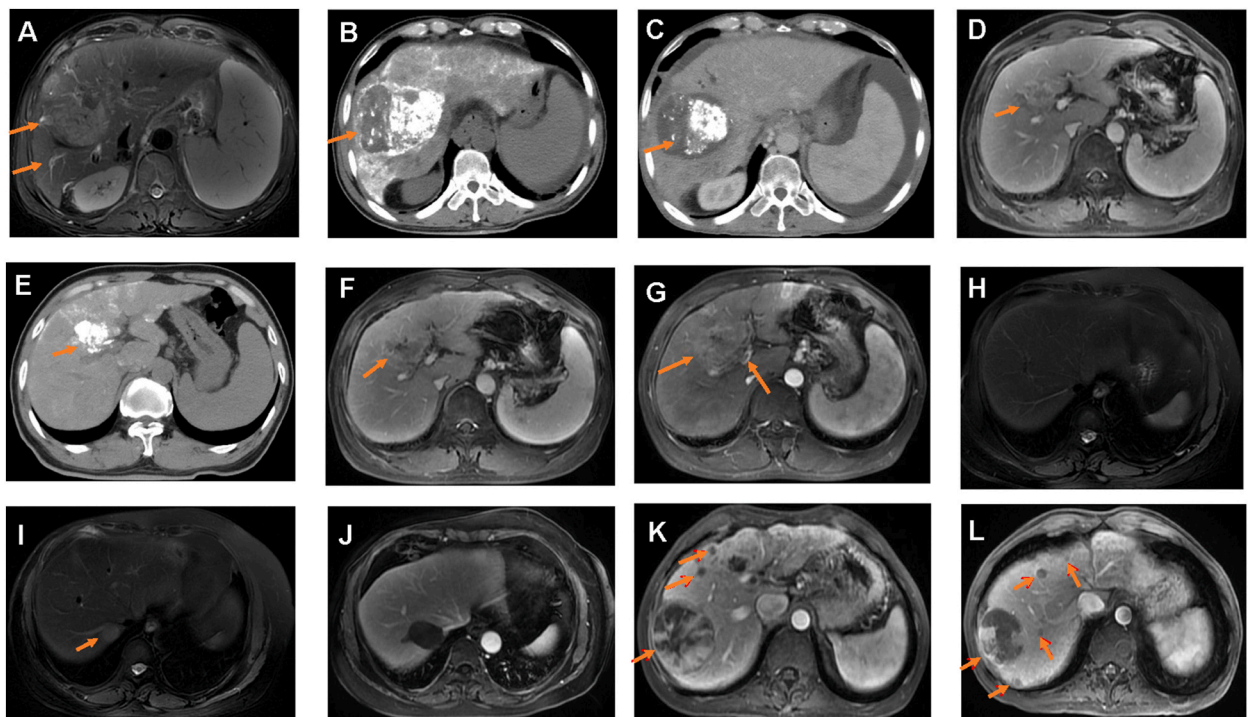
Dynamic imaging results from 4 clinical cases. (A–C) Case 1, this case became remission. (D–G) Case 2, this case progressed with enlarged tumor. (H–J) Case 3, this case progressed from liver cirrhosis to HCC and finally became remission. (K–L) Case 4, this case progressed with new lesions. (A) Case 1, initial imaging results with elevated AFP, AFP-L3, and PIVKA II. MRI showing two lesions of HCC (arrows). (B) Case 1, CT showing a tumor with parenchymal iodized oil deposition (tumor size 10.5 × 9.5 cm) (arrow). (C) Case 1, CT showing an inactive lesion. (D) Case 2, MRI showing an active lesion, tumor size 3.5 × 3.1 cm (arrow). (E) Case 2, MRI showing this lesion size becoming 3.2 × 3.0 cm after radiofrequency therapy. (F) Case 2, a larger lesion size was observed (arrow), with tumor size 3.5 × 4.0 cm. (G) Case 2, this pre-present lesion became larger (4.9 × 6.1 cm) and PVTT appeared. (H) Case 3, MRI showing no HCC detection in this case. (I) Case 3, this case was diagnosed as HCC with a single lesion (arrow). (J) Case 3, No active lesion was observed and this case went into remission. (K) Case 4, multiple lesions were located in the right liver lobe (arrows). (L) Case 4, a new lesion was detected in the right liver lobe relative to that before MRI imaging (arrows). PVTT, portal vein tumor thrombus.
